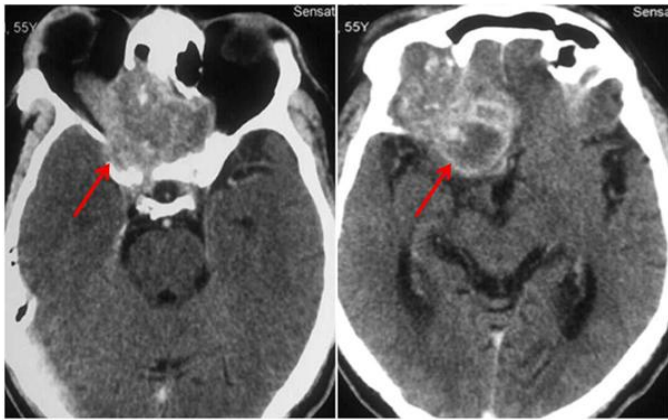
CT PNS axial section with pan sinusitis showing intracranial extension with right frontal abscess.
